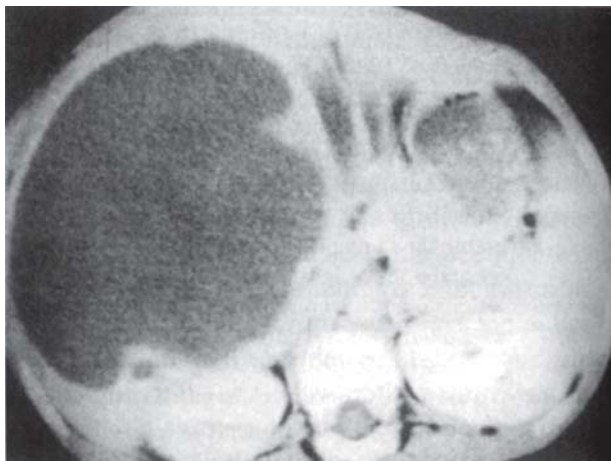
CT scan (contrast enhanced) showing a large hypodense area (right lobe of liver) consistent with a solitary amebic liver abscess
